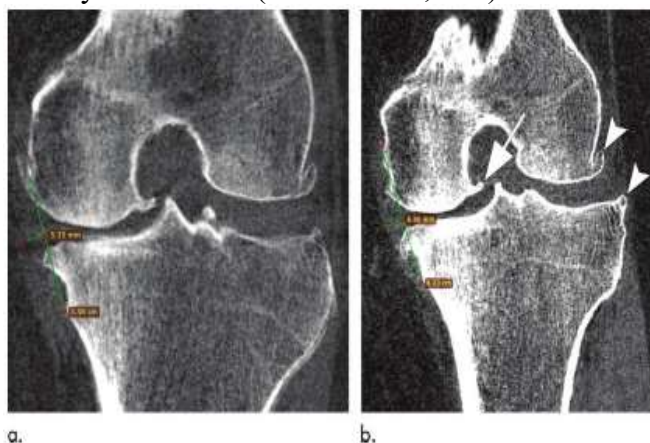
Coronal cone-beam CT images of a 58-year-old man in the non-weight-bearing (a) and weight-bearing (b) positions. Medial meniscal extrusion is observed, measuring 5.35
